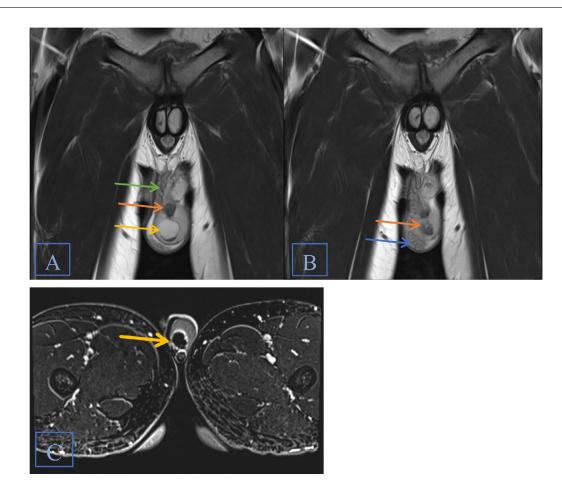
(A and B) MRI T2-weighted images (coronal cut) showing the tubular ectasia of left rete testis (orange arrow), enlarged epididymis (blue arrow), and dilated tortuous ductus deferens (green arrow). In addition, there is an intratesticular hematoma at the inferior pole of the left testis with a small air-fluid level (yellow arrow). (C) Subtracted postcontrast T1-fat suppression image demonstrating intratesticular hematoma with peripheral enhancement (yellow arrow).
